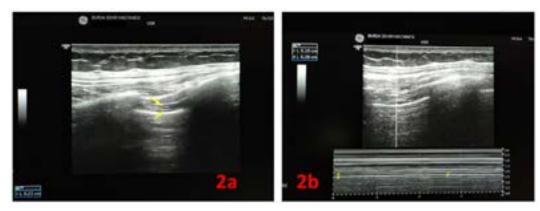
Diaphragm ultrasonography. 2a: measuring diaphragm thickness (DT) in B mode (yellow arrows shows the distance between the diaphragmatic pleura and the peritoneum); 2b: diaphragm thickening fraction (TF) the percentage change in diaphragm thickness in M mode.
